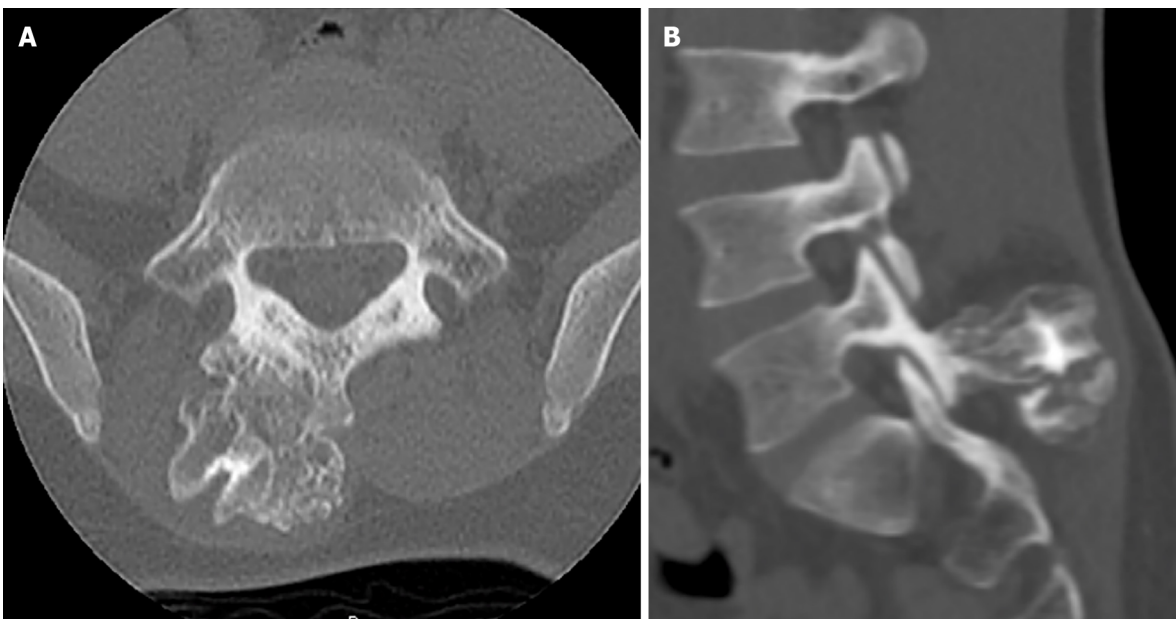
Computed tomography images. A: Axial computed tomography imaging demonstrating osteochondroma protruding from right spinous process/Lamina junction; B: Sagittal computed tomography imaging at the level of the L5/S1 facet joint depicts mass involvement of the right inferior articular process of L5. An ultrasonic bone scalpel was used to remove the mass *en bloc* from the articular process without disrupting the facet capsule.
